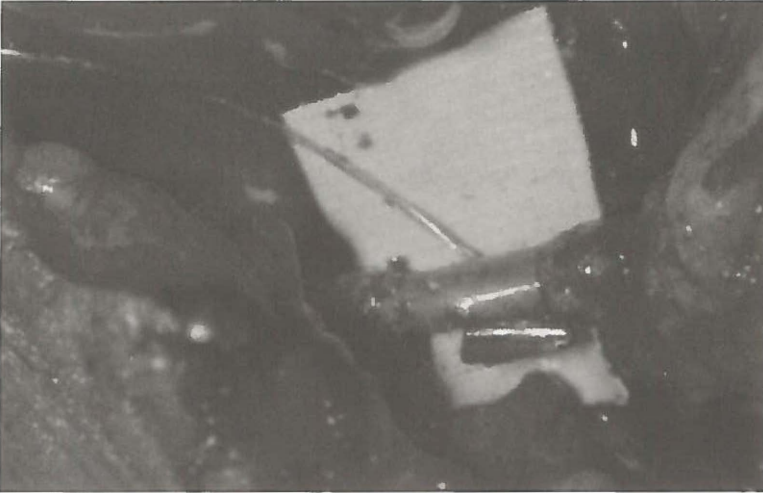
The silicone cuff with the Doppler crystal wrapped around the vein. The cuff is positioned distal to the anastomoses. The Doppler signal leaves the body through the wire attached to the cuff; this wire can be removed 5 to 10 days after surgery by applying a tension of 50 g. (Courtesy of Cook Medical, Cook Ireland Ltd., Limerick, Ireland).
